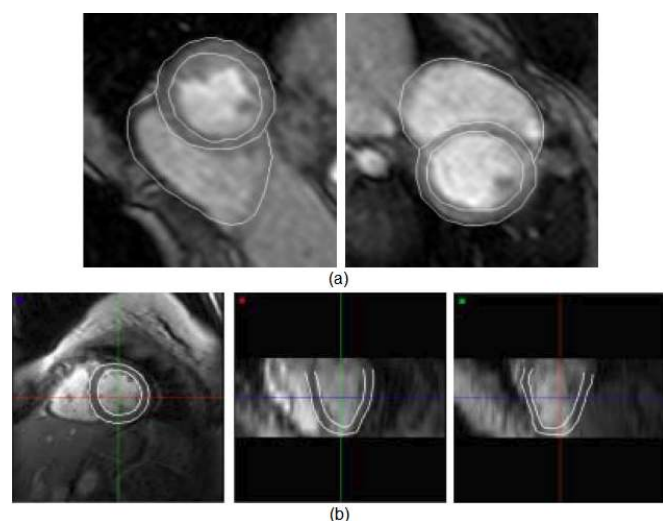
Segmentation of ventricle borders in cardiac MRI images. (a) LV and RV contours extracted by a multistage hybrid method [163], and (b) LV borders detected by a deformable model in three orthogonal views from the end-diastolic phase [159].
